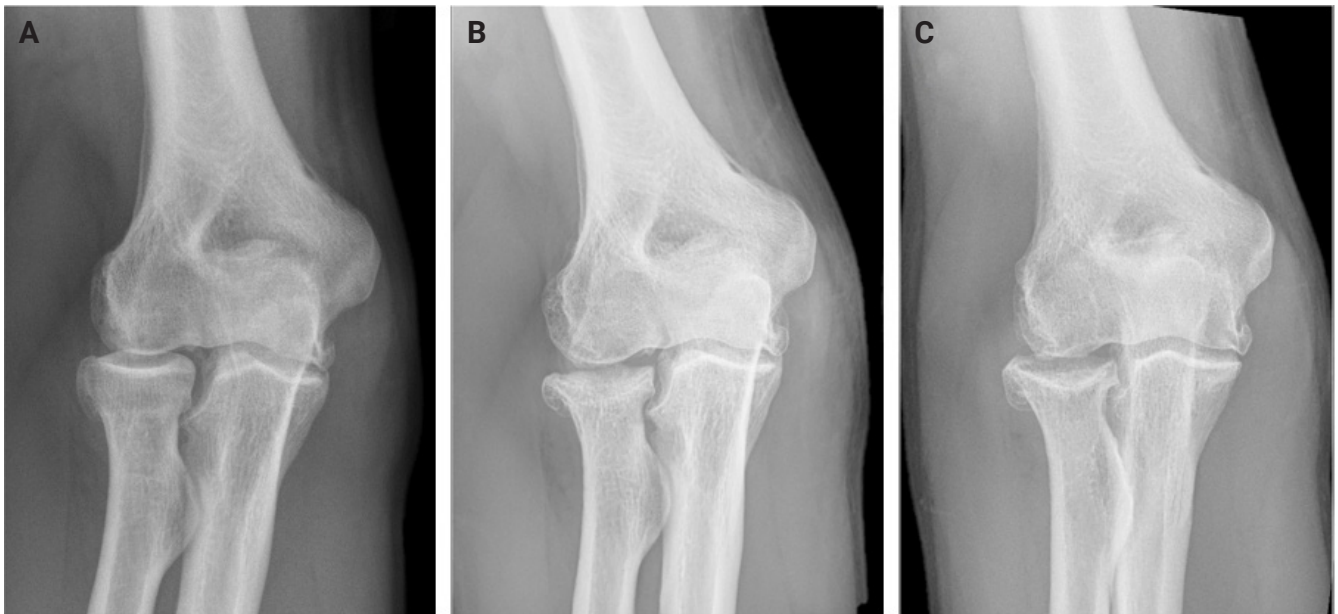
(A) Preoperative, (B) 4 months and (C) at 2.5 years postoperative anteroposterior elbow radiographs of patient no. 4. No renarrowing was observed.
